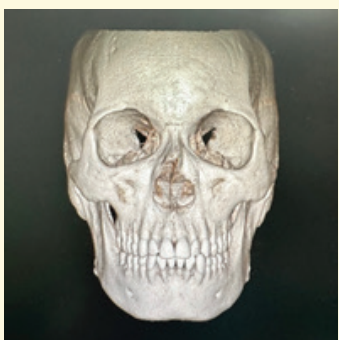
displays a 3-D CT scan. (Frontal view)
